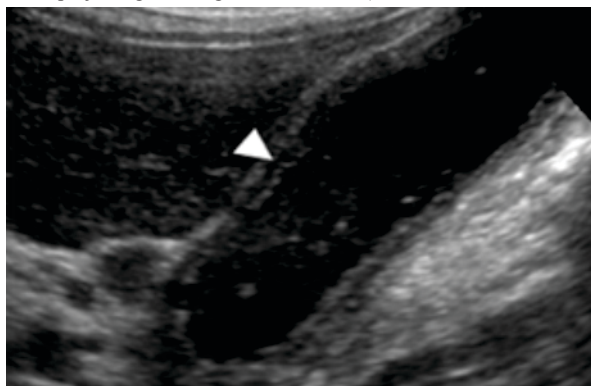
Ultrasound appearance of a tram track pattern (central hypoechoic zone separated by two echogenic layers).
